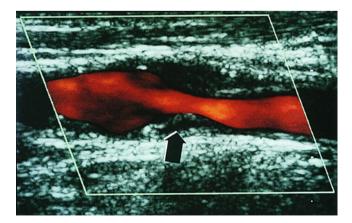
A color duplex ultrasound image of the carotid artery showing a smooth heterogeneous plaque (*arrow*). The dark center of the plaque may represent intraplaque hemorrhage
